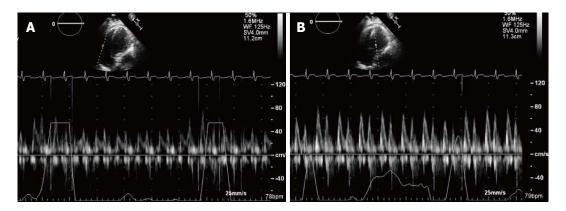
Apical four chamber view of transthoracic echocardiogram and pulse wave Doppler's recording. A: Tricuspid valve inflow in a patient with constrictive pericarditis; B: Mitral valve inflow in a patient with constrictive pericarditis. Note with inspiration, the E-wave velocity of mitral valve inflow decreases significantly. This reflects the hemodynamic changes in constrictive pericarditis, resulting from the lack of intrathoracic pressure transmission to the cardiac chambers and the exaggerated ventricular interdependence.
